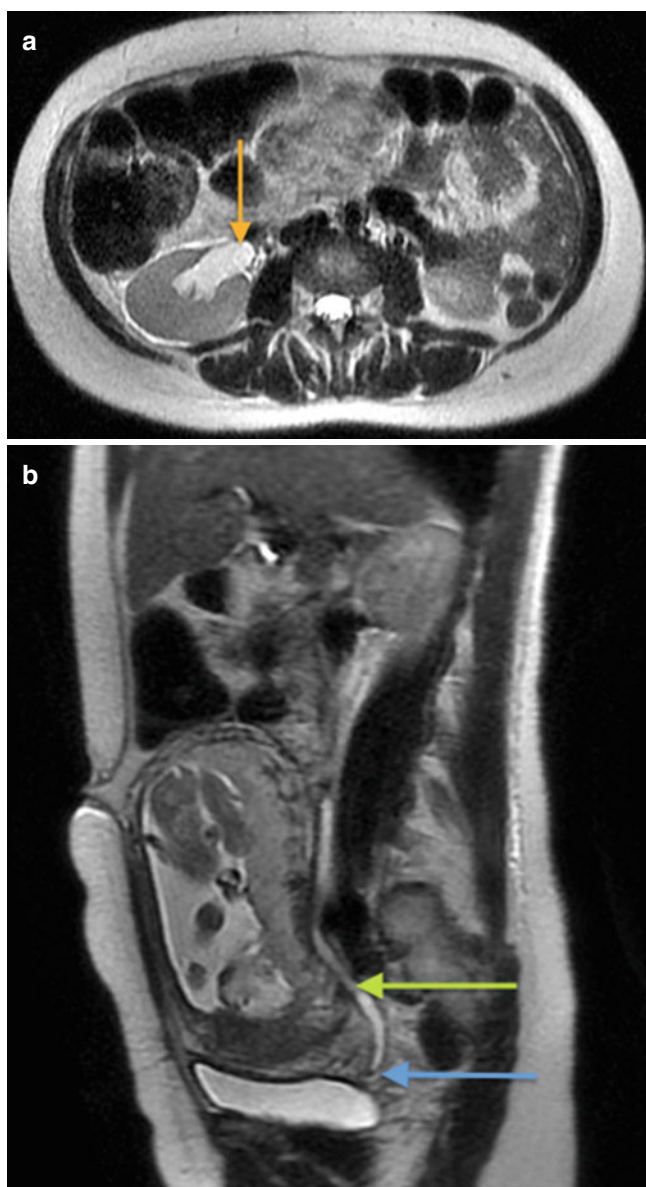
Obstructing right ureteral calculus in a pregnant patient. Axial (a) and sagittal (b) T2-weighted images demonstrate mild right hydronephrosis (orange arrow) and hydroureter (green arrow) secondary to a low-signal distal right ureteral calculus (blue arrow). A gravid uterus is noted. In hydronephrosis of pregnancy, the ureter usually shows gradual tapering at the level of the pelvic brim, as opposed to this example, where the ureter remains dilated down to the ureterovesical junction
